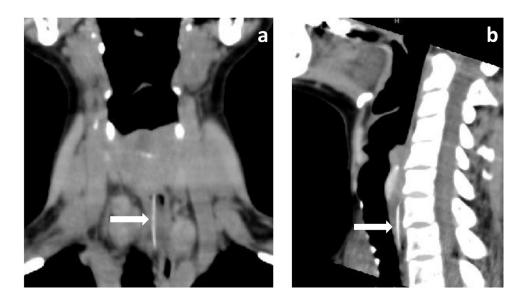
The plain abdominal computed tomography (CT) images, coronal and sagittal planes. This image showed a linear calcification (arrows in this figures) and surrounding esophageal wall thickening consisted with co-existing inflammation. (a) Coronal plane, (b) sagittal plane.
